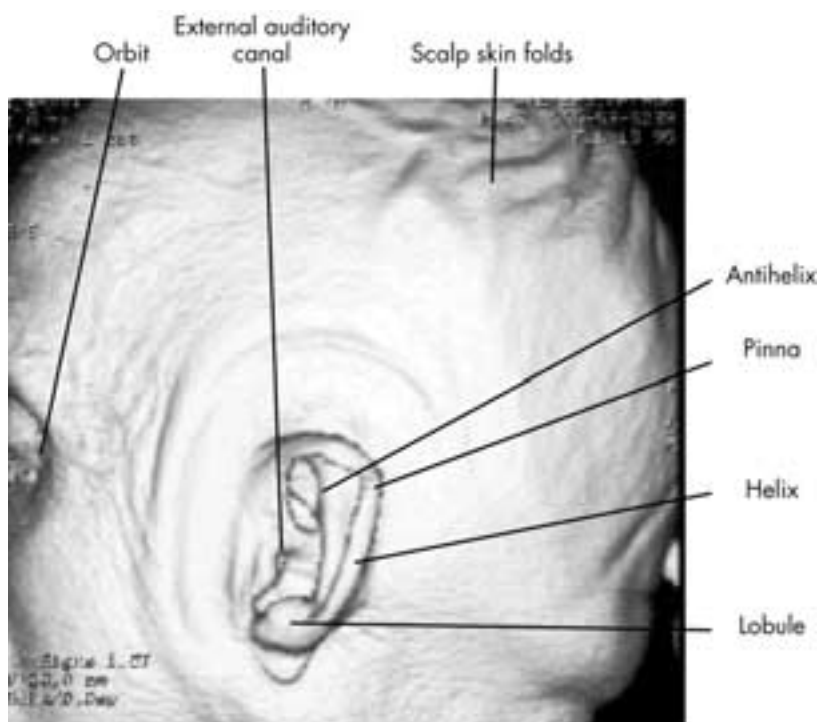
Surface MR imaging, reconstruction of the pinna. This is a surface volume reconstruction of an axial MR imaging 3DFT data set of 60 images. The head is viewed from laterally. The image suggests that the patient is bald, but this is due to the lack of signal from hair. Many of the details of the surface anatomy are accurately displayed. All of the deep anatomy is also available for analysis.
